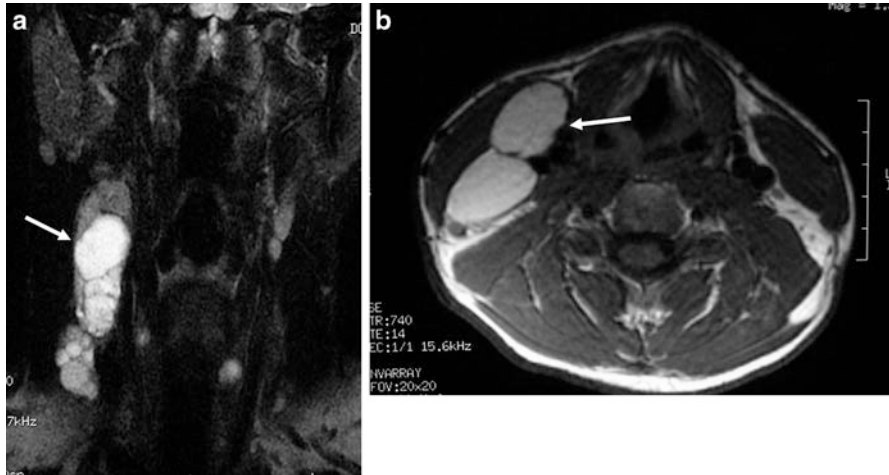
MR imaging of the neck. Cystic nodal metastases from occult papillary thyroid carcinoma. The typical cystic changes with hyperintensity on both T2 (a) and T1 (b) sequences are well depicted (arrows)
